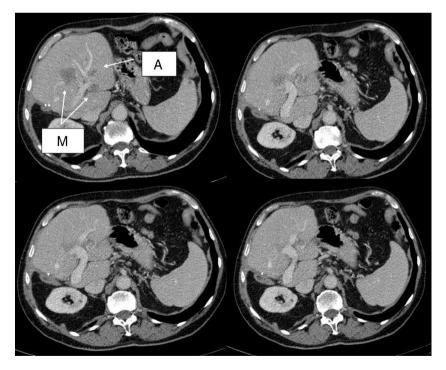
Initial CT scan showing the metastasis in segment IV in contact with the left portal vein and encompassing the portal branch of the segment, one of the metastases in segment II (M) and an angioma (A).
